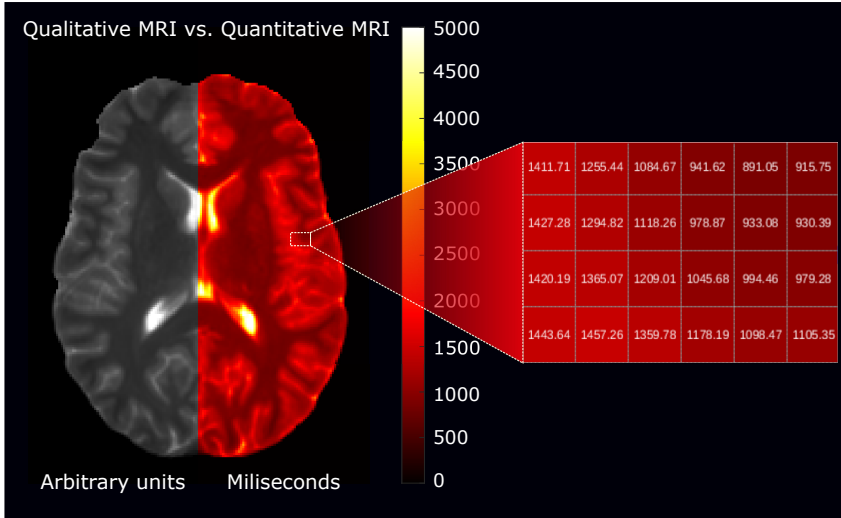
Differences between qualitative MRI (i.e., weighted images) and quantitative MRI (i.e., parametric maps). The intensity of weighted images does not present units, whereas parametric maps present an absolute scale, measured in milliseconds in the T1 map shown in the image.
